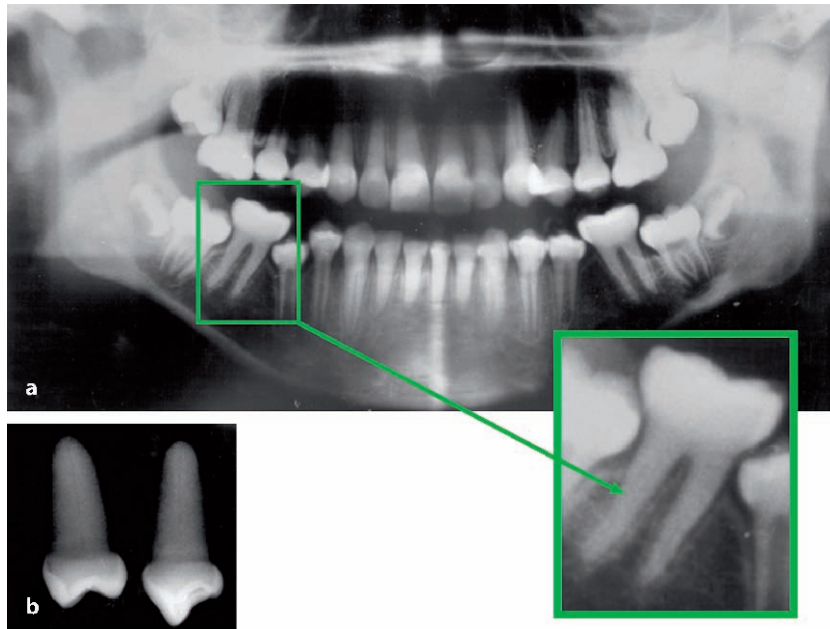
Type II dentinogenesis imperfecta. a Panoramic radiograph demonstrates teeth throughout the dentition have narrow spindly root, rapid sclerosis of the pulp chamber and root canals, and bulbous crowns. b Radiograph of extracted teeth showing detail of early pulpal sclerosis
